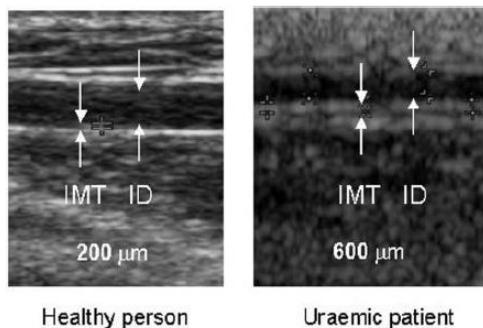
B-mode ultrasonography shows intima-media thickness (IMT) and internal diameter of the radial artery in a uremic patient and a healthy person. IMT is the distance between blood-intima and media-adventitia interface at the far wall of the straight portion at the just above the wrist. See increased IMT of the uremic patient, compared to the control.
